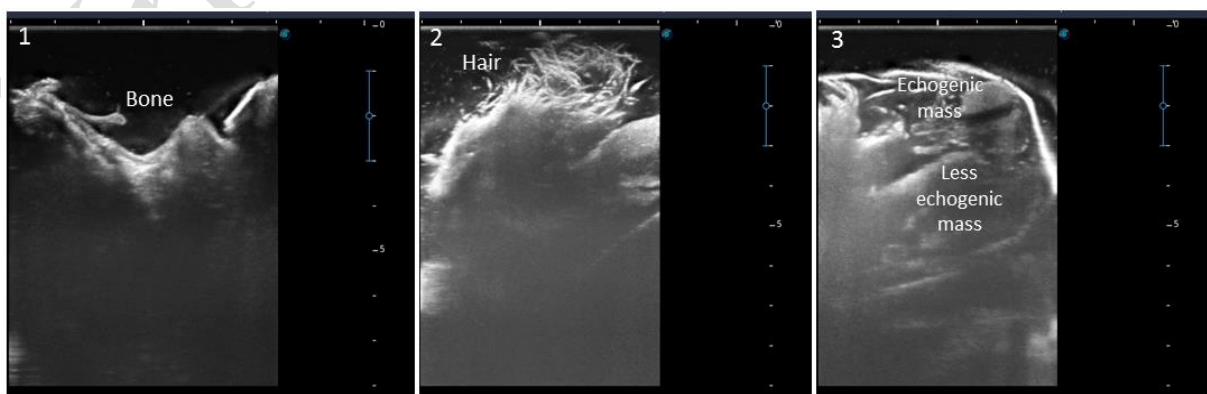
Ultrasonography (US) of a mature cystic teratoma shows a heterogeneous image with echogenic dispersed reflectors suggesting hairs, calcifications assuming bone, and echogenic spherical masses supposing fat balls and clotted materials.
